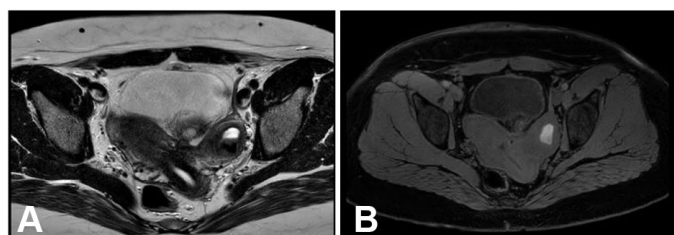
(A and B) T2 and T1 MRI image of the congenital anomaly with a unicornuate uterus (right cavity normal) and a hypoplastic, non-communicating left horn; dilation of the left horn containing blood. Discrete hemorrhagic endometriosis foci adjacent to the serosa on the left.
